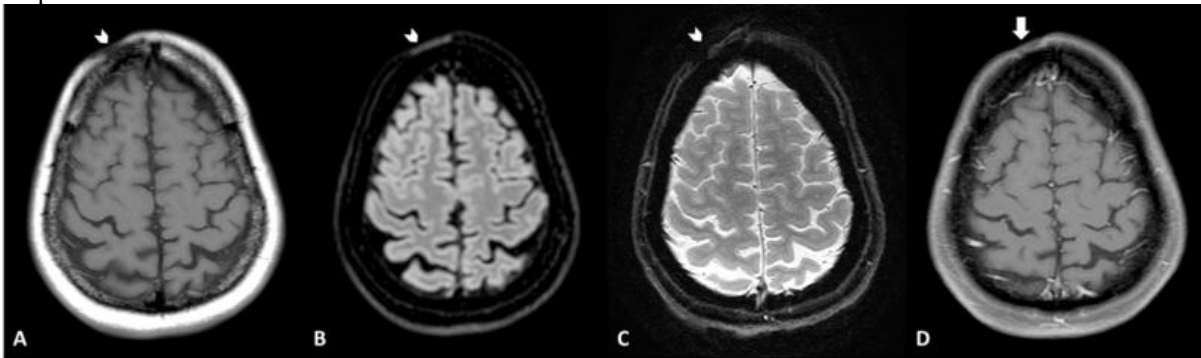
MR images of a 45 year-old woman with linear scleroderma *en coup de sabre* without Parry Romberg Syndrome. Axial T1 (A), FLAIR (B) and GRE (C) weighted MR image demonstrate right frontal atrophy of the skin and subcutaneous fat (arrow head). D, Axial enhanced T1-weighted MR image demonstrates mild enhancement of skin and subcutaneous fat (thick arrow). There is no involvement of the central nervous system.
